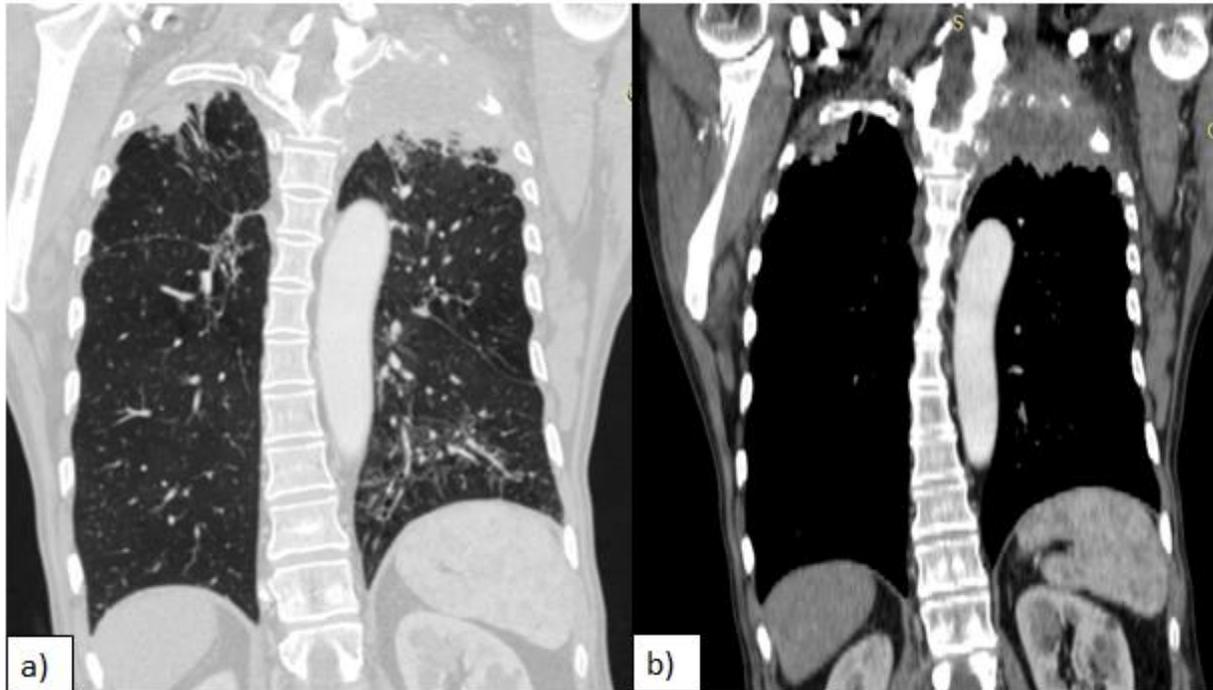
a)Lung window and b) Post contrast mediastinal window : Axial CT images shows the left apical mass which extra-thoracic extension.
